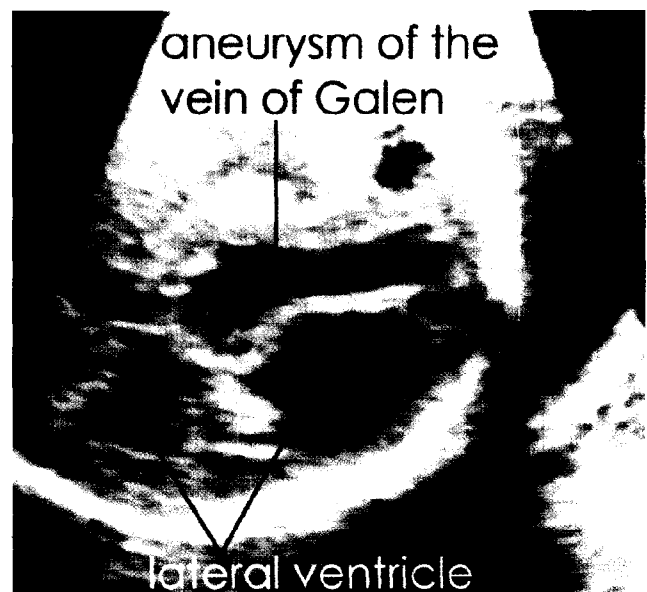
Case 20: aneurysm of the vein of Galen is an obvious diagnosis from color Doppler ultrasound. The lateral ventricles are enlarged. The increased echogenicity of the white matter is thought to represent brain edema
